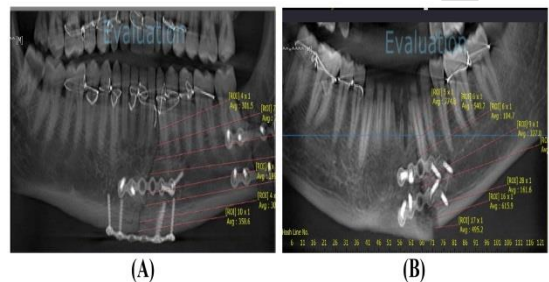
Postoperative CBCT-scan (A: two perpendicular mini-plates, B: two conventional mini-plates).
